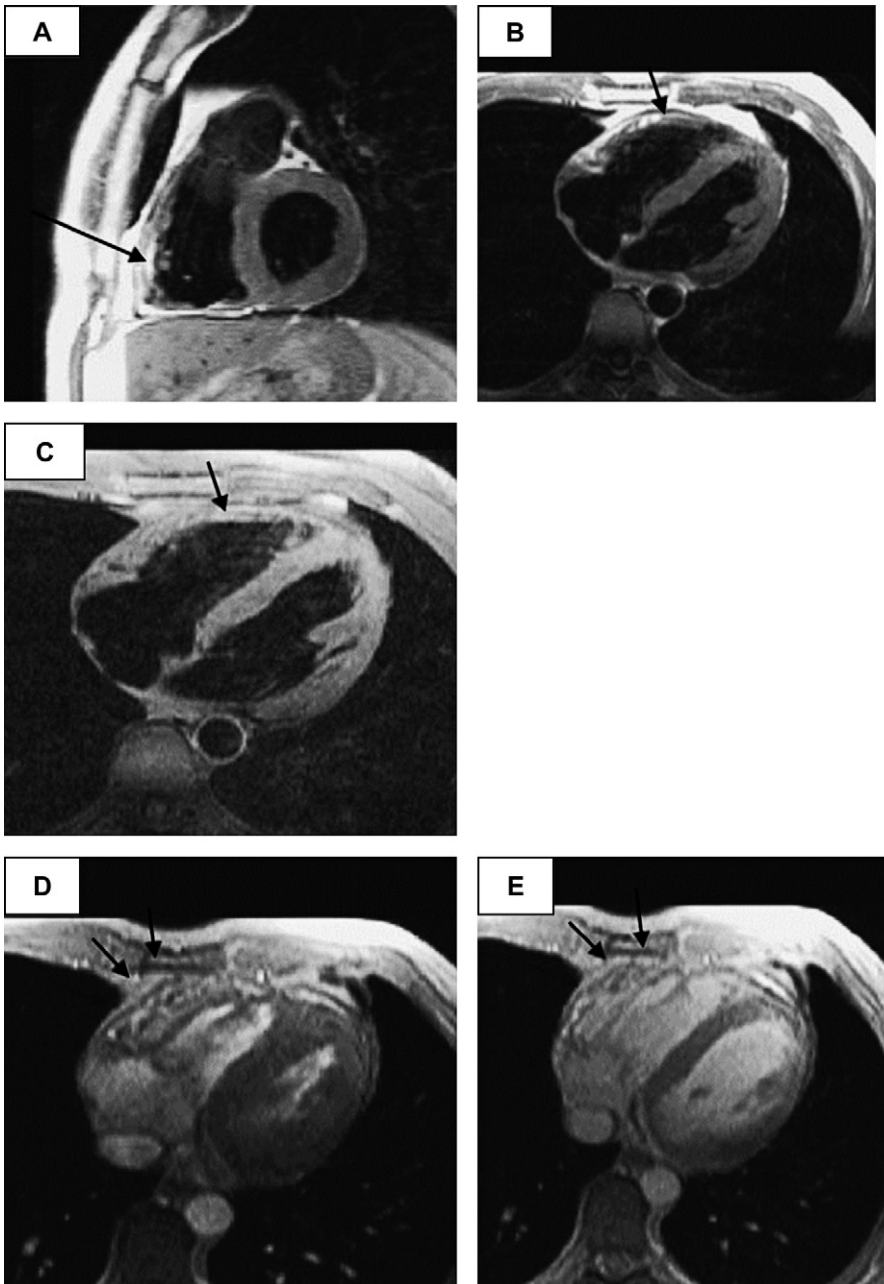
Cardiovascular magnetic resonance imaging for the diagnosis of arrhythmogenic right ventricular dysplasia. T1-weighted turbo spin-echo sequences show the high signal intensity (bright) region within the right ventricular (RV) anterior wall in a left ventricular (LV) short-axis (A) and axial (B) view (arrows). Signal intensity of this region is comparable to that of subcutaneous fat. With application of a fat suppression pulse, the bright signal of the fatty infiltrates disappear, again comparable with subcutaneous fat (C) (arrow). End-systolic (D) and end-diastolic (E) frames from a cine gradient echo sequence demonstrate the RV dilation and the impaired inward motion and systolic thickening of the RV anterior wall (arrows). (From Keller D, Osswald S, Bremerich J, et al. Arrhythmogenic right ventricular dysplasia: diagnostic and prognostic value of cardiac MRI in relation to arrhythmia free survival. *Int J Card Imaging* 2003;19:537; with permission.)
